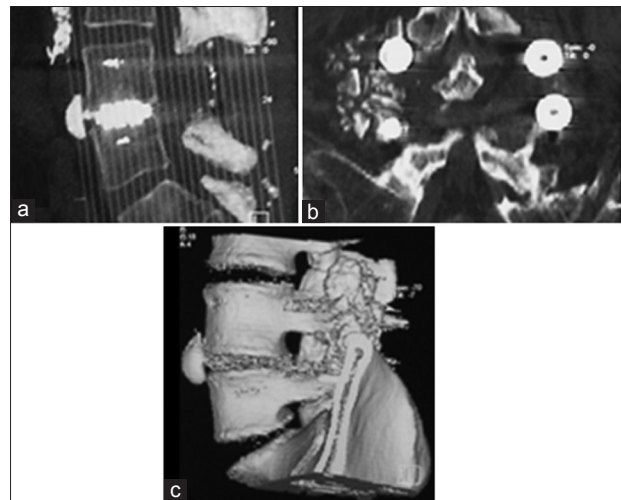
Follow-up CT images with 3-D reconstruction showing solid fusion (B Twin system) (a) Sagittal image; (b) Axial image and (c) 3d reconstruction
